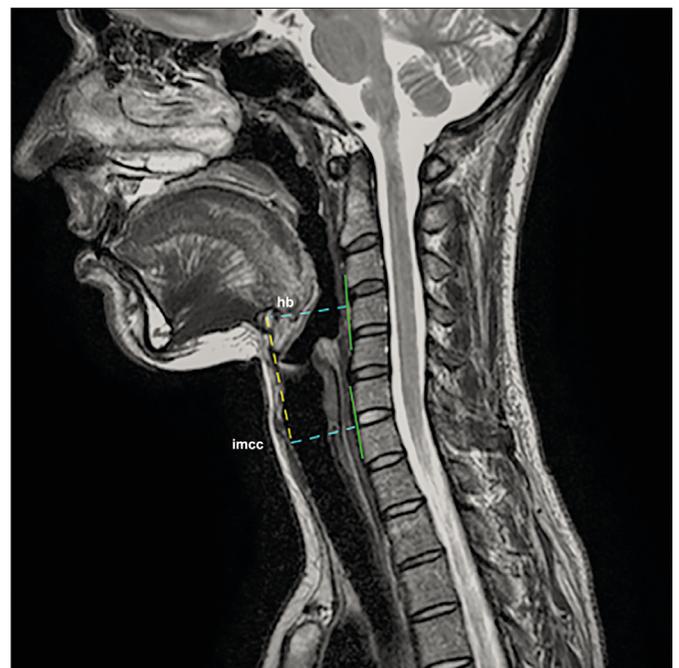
Magnetic resonance imaging, sagittal plane, T2-weighted. Green line: roughly parallel line to the anterior surface of the cervical vertebrae bodies; blue line: projection of the hyoid bone and inferior margin of cricoid cartilage to the cervical spine; yellow line: distance between the hyoid bone and the inferior margin of cricoid cartilage (length of the laryngeal framework).
